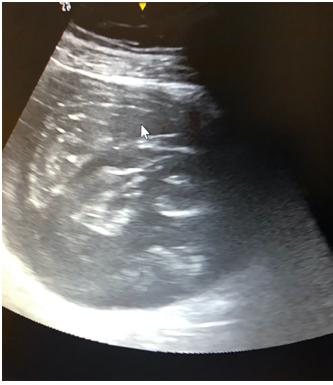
Ultrasound examination showing a voluminous septate cystic mass.
